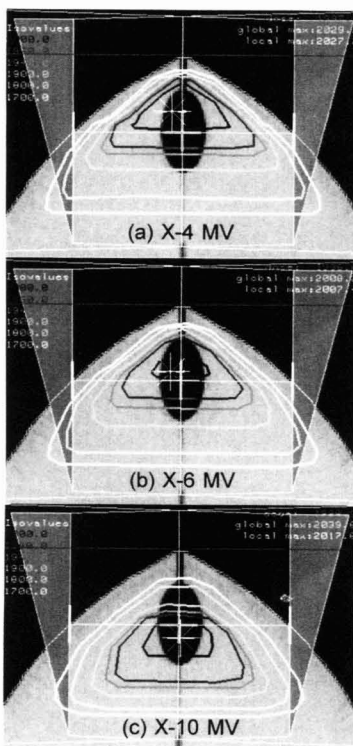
CT-based computer generated dose distributions by treatment planning system (FOCUS) in 4, 6, 10 MV x-rays.
